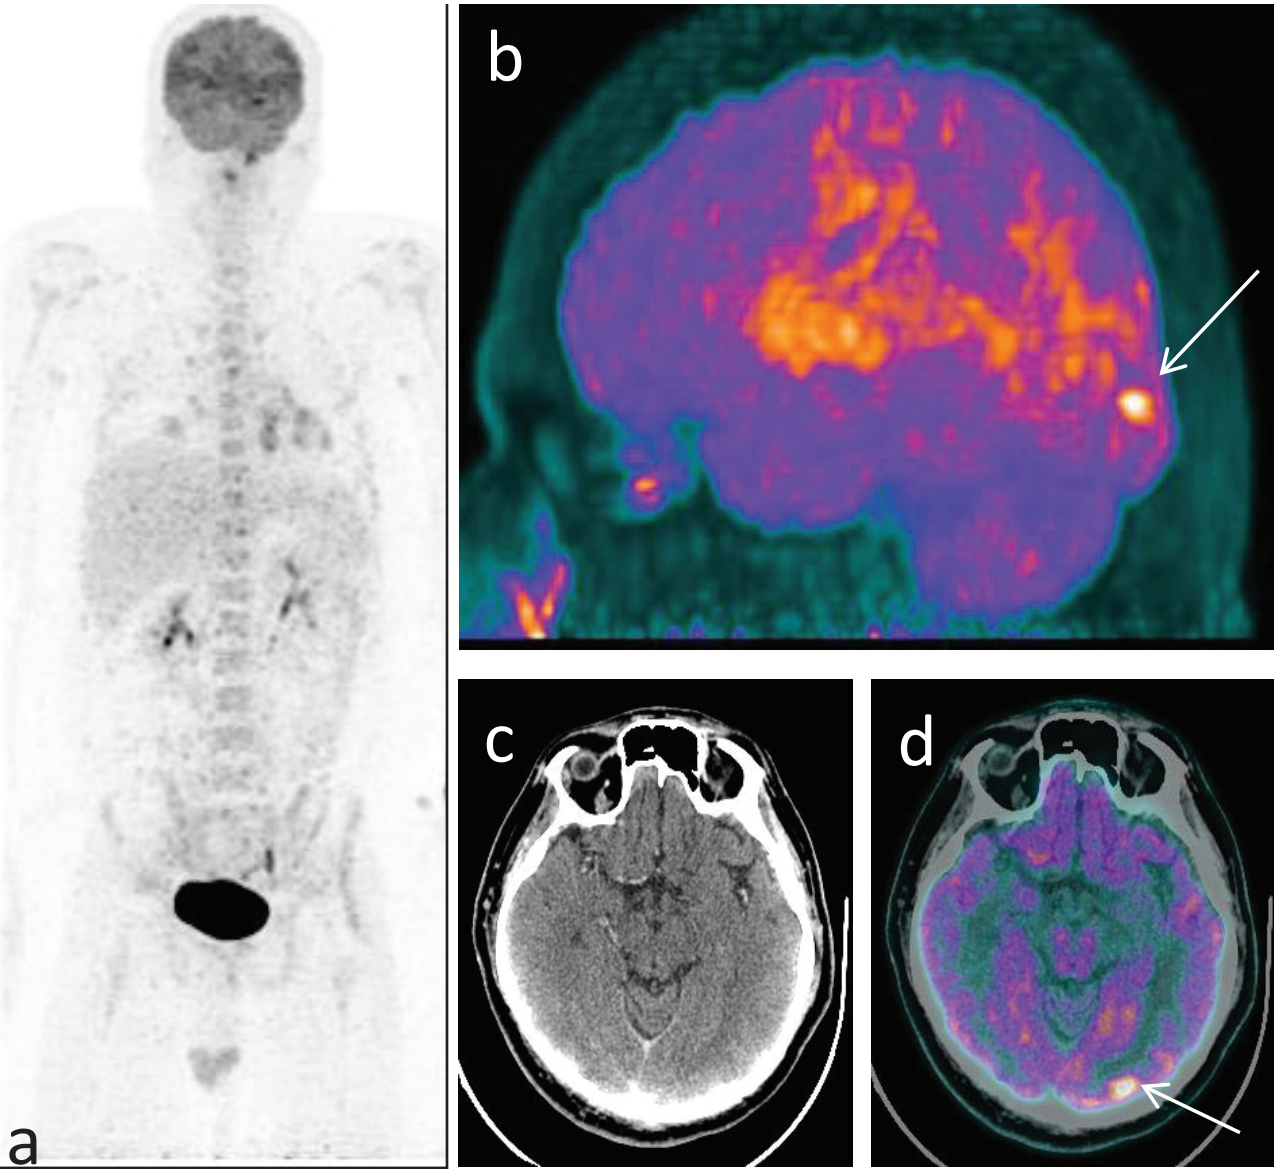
Shows 18F-FDG PET CT whole body maximum intensity projection (MIP) (a), brain PET MIP (b), brain CT (c) and fused axial brain PET CT section (d), showing abnormal focal increased tracer uptake in left occipital region (white arrow).
